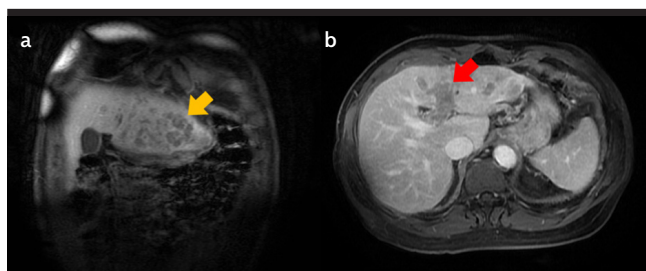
a, b. Abdominal MRI at HCC diagnosis. a) Nodular and heterogeneous area involving the left liver lobe with diffusion restriction and washout in the venous phase (yellow arrow). b) Left-branch portal vein thrombosis (red arrow).
